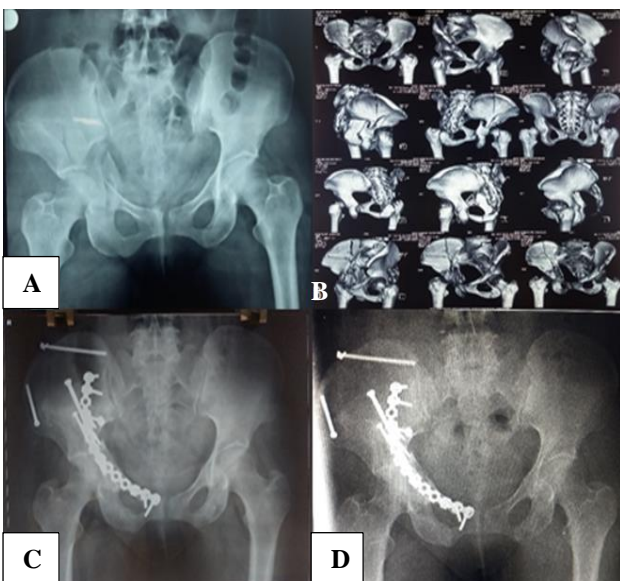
34-year-old female right sided ACPHT fracture (A) pre-op X-ray; (B) pre-op CT scan; (C) immediate post-op X-ray; and (D) 6 months' post-op X-ray.
